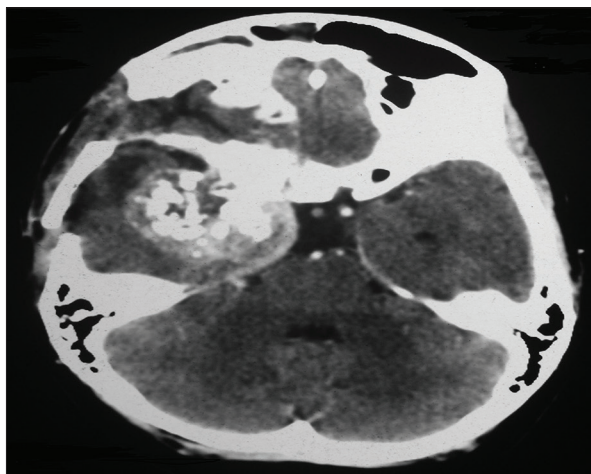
Postoperative computed tomography scan of brain and orbit revealed a large soft tissue density mass near the floor of middle cranial fossa on the right side
